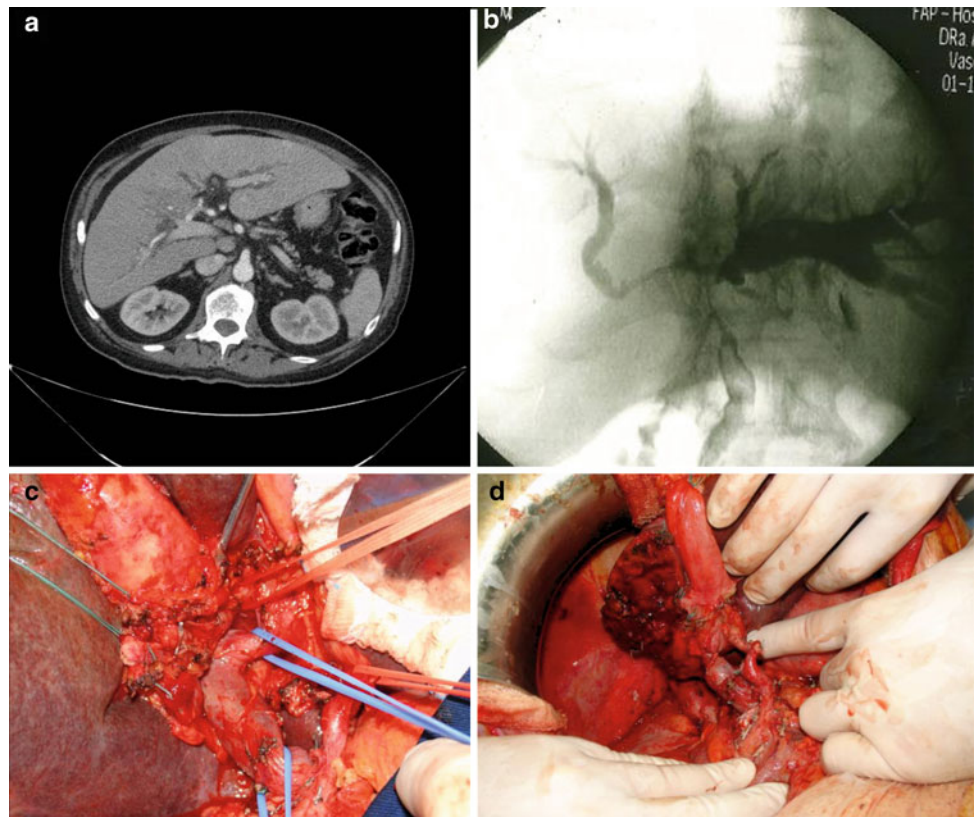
A Hilar cholangiocarcinoma Bismuth–Corlette type IIIB treated by left lobectomy and caudate resection. a Abdominal CT showing the extension of the tumor to the left main duct. b–d Intraoperative view after liver transection with hanging liver approach, resection of the caudate lobe, and intrahepatic bilioenteric anastomosis
